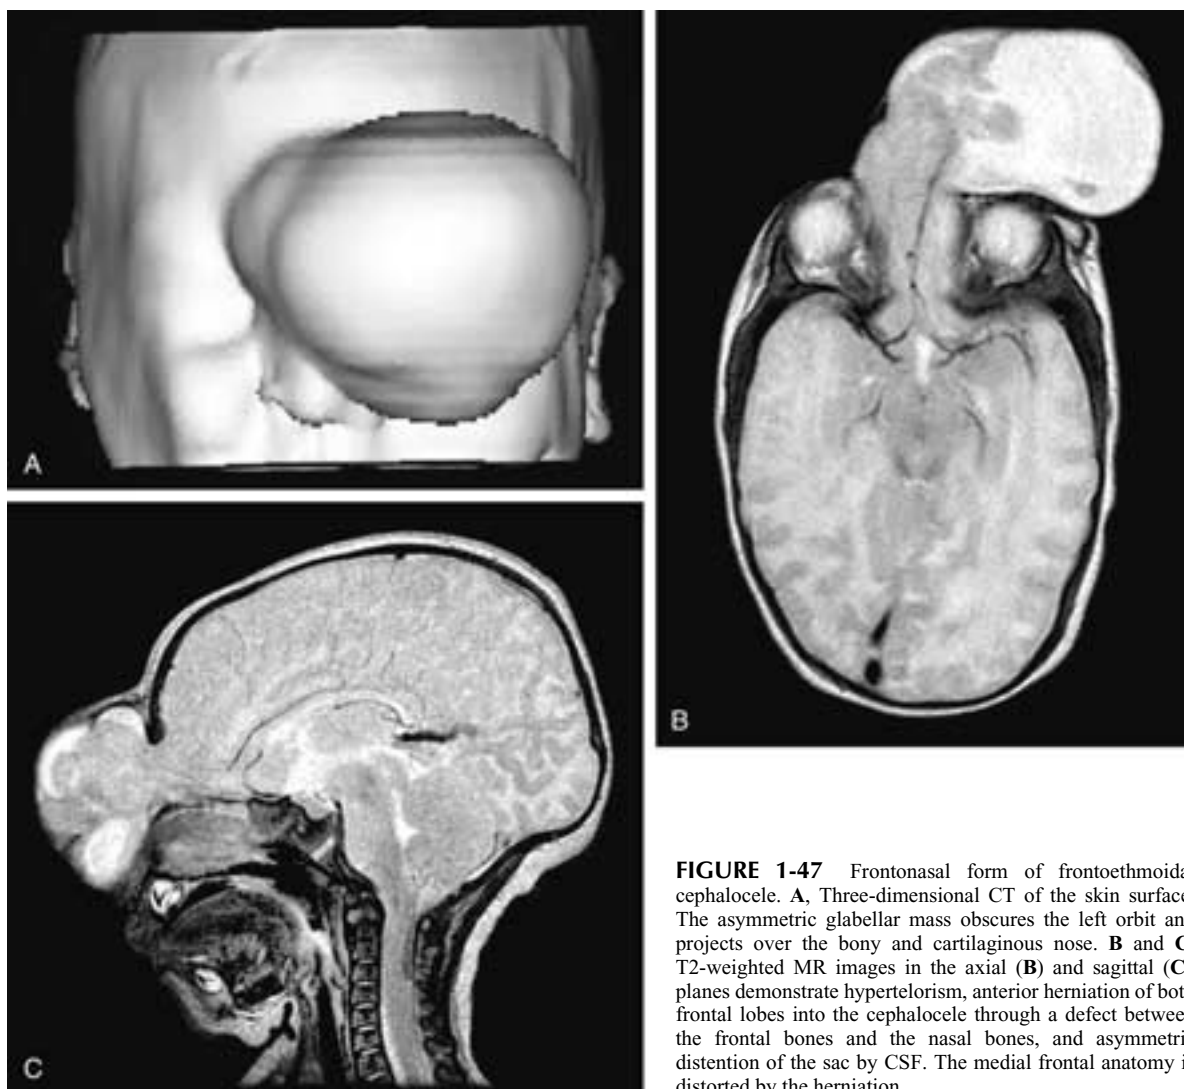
Frontonasal form of frontoethmoidal cephalocele. A, Three-dimensional CT of the skin surface. The asymmetric glabellar mass obscures the left orbit and projects over the bony and cartilaginous nose. B and C, T2-weighted MR images in the axial (B) and sagittal (C) planes demonstrate hypertelorism, anterior herniation of both frontal lobes into the cephalocele through a defect between the frontal bones and the nasal bones, and asymmetric distention of the sac by CSF. The medial frontal anatomy is distorted by the herniation.
